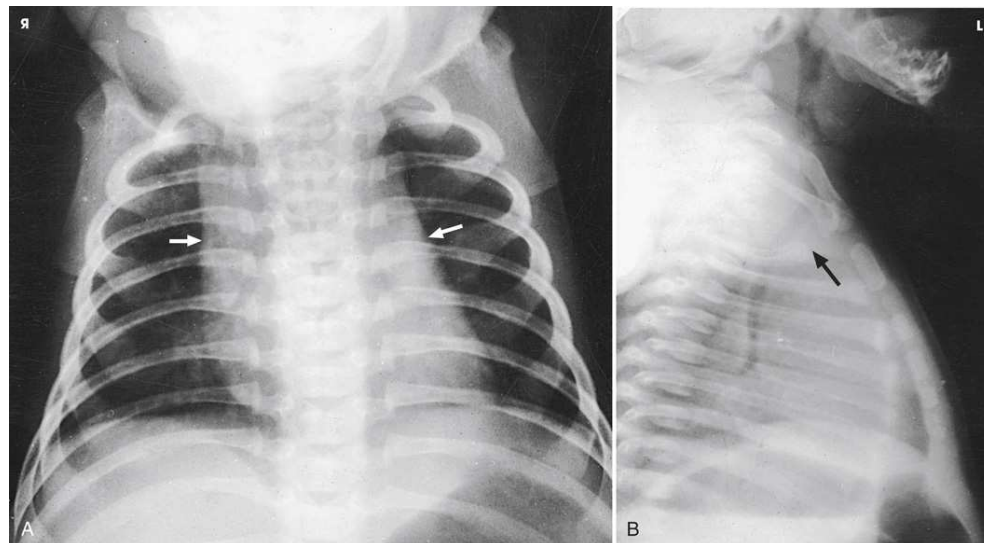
(A) PA chest radiograph showing mediastinal enlargement caused by hypertrophy of thymus (arrows). (B) Lateral chest radiograph showing enlarged thymus (arrow).
